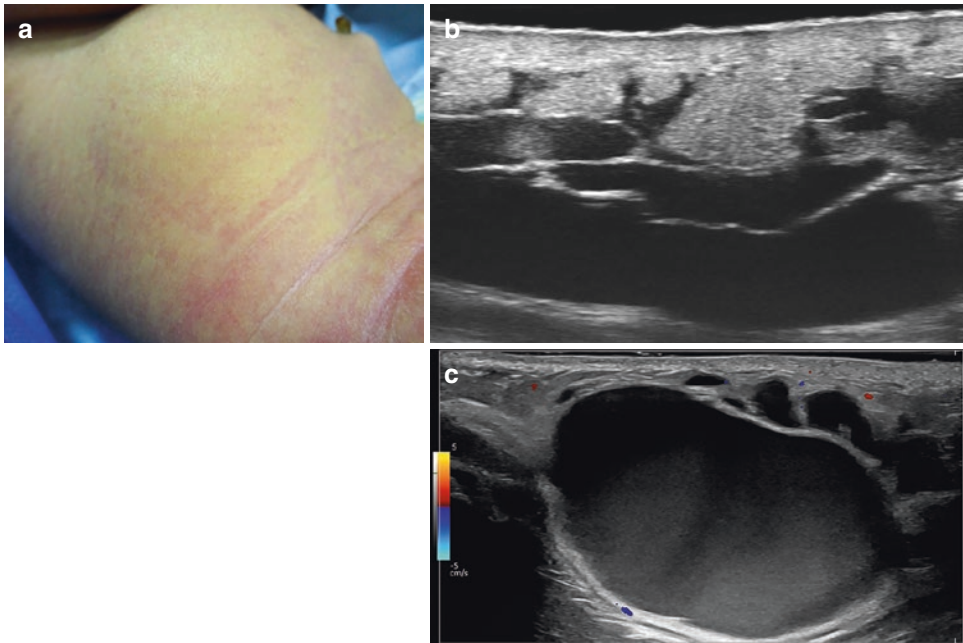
Low-flow lymphatic vascular malformation. (a) Clinical picture of the right side of the abdominal wall in a 1-year-old child. (b) Grayscale ultrasound (70 MHz; transverse view) demonstrates multiple lacunar hypodermic spaces of different sizes and with some branches. (c) Color Doppler ultrasound (24 MHz) shows no presence of flow within the lacunar spaces
